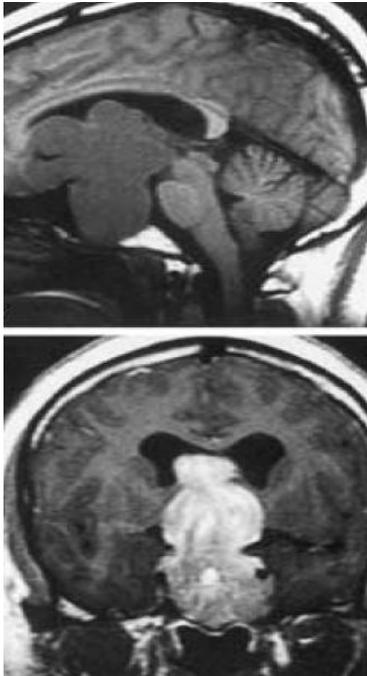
Pituitary macroadenoma ,MRI brain & pituitary fossa (sagittal plain T1W sequence & coronal T1post contrast), showing large lobulated pituitary mass causing mass effect on optic chiasm & extending in to 3rd and lateral ventricles with involvement of both cavernous sinuses specially the left one. Homogenous post contrast enhancement is noted.
